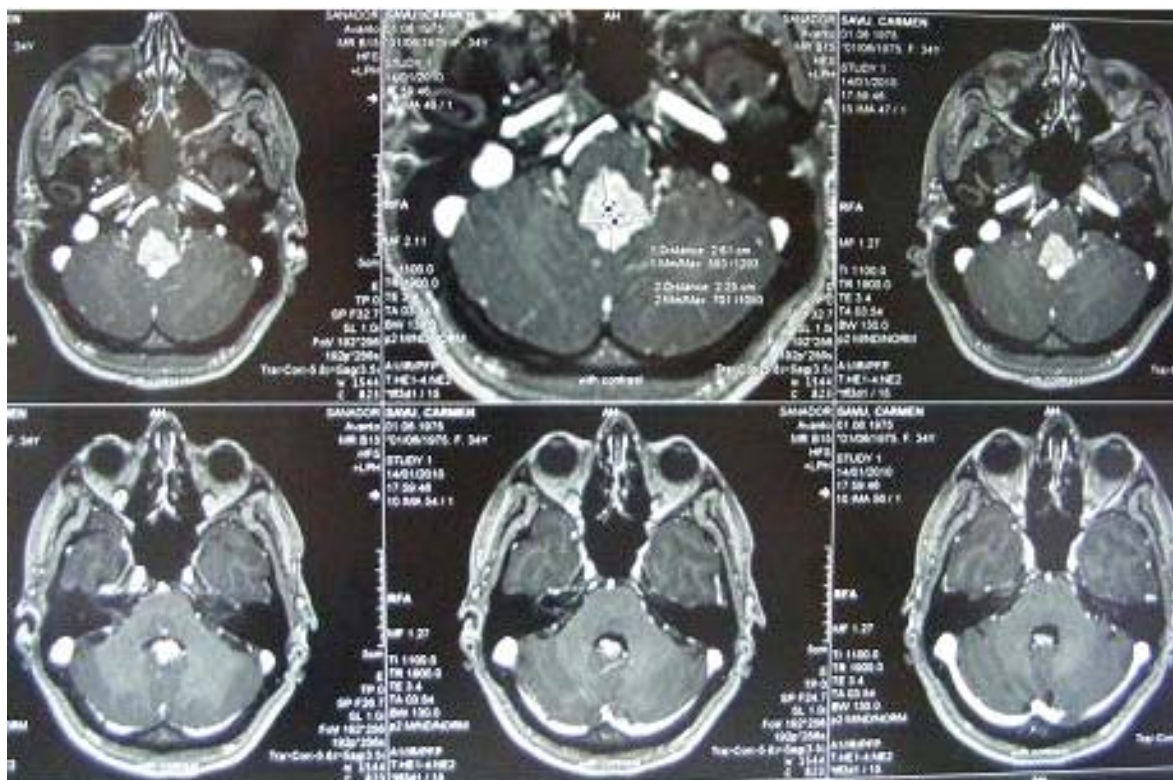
Preoperative MRI –scan (axial incidence)
